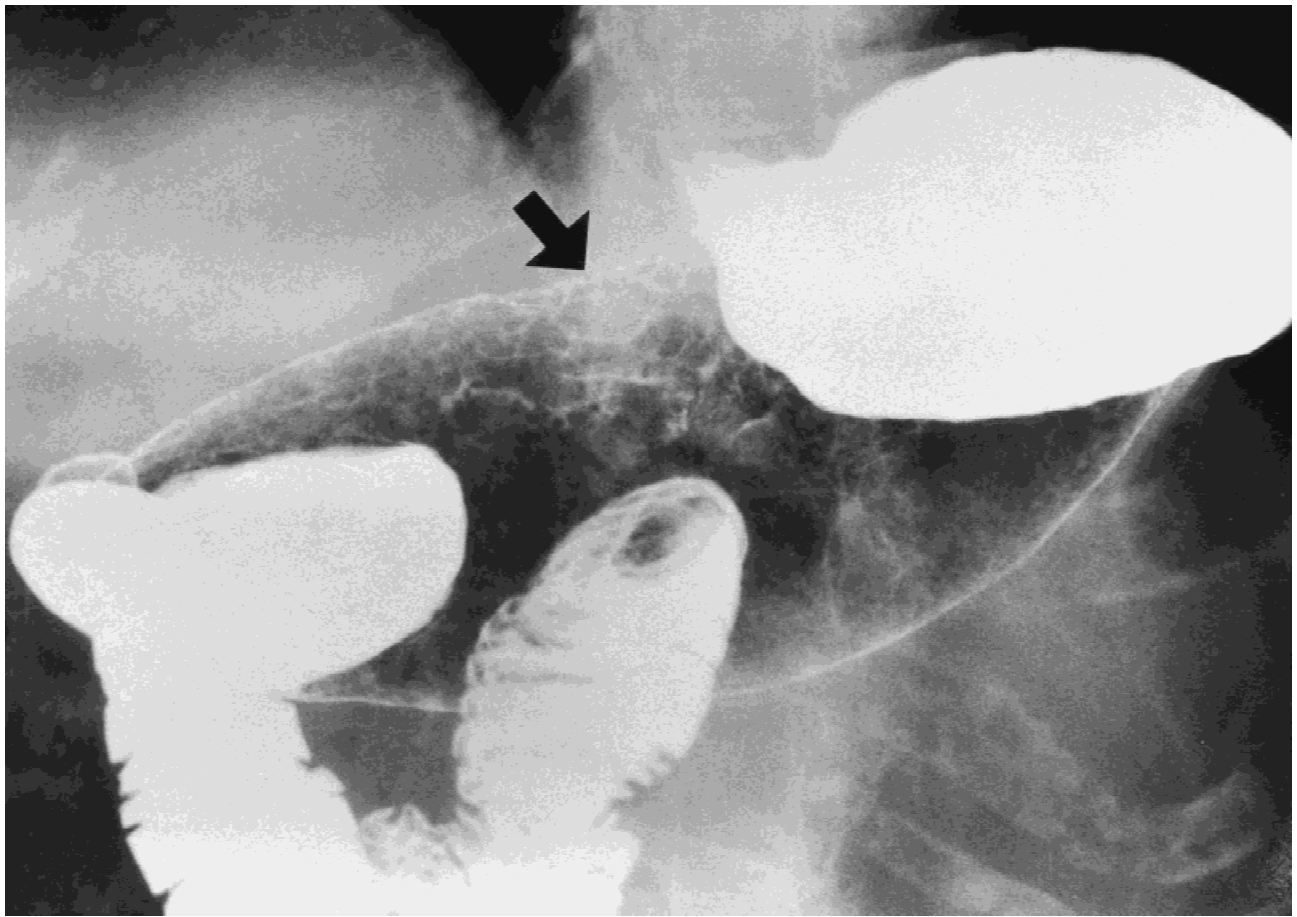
Upper gastrointestinal radiograph shows polypoid lesion (arrow) of the lesser curvature.
